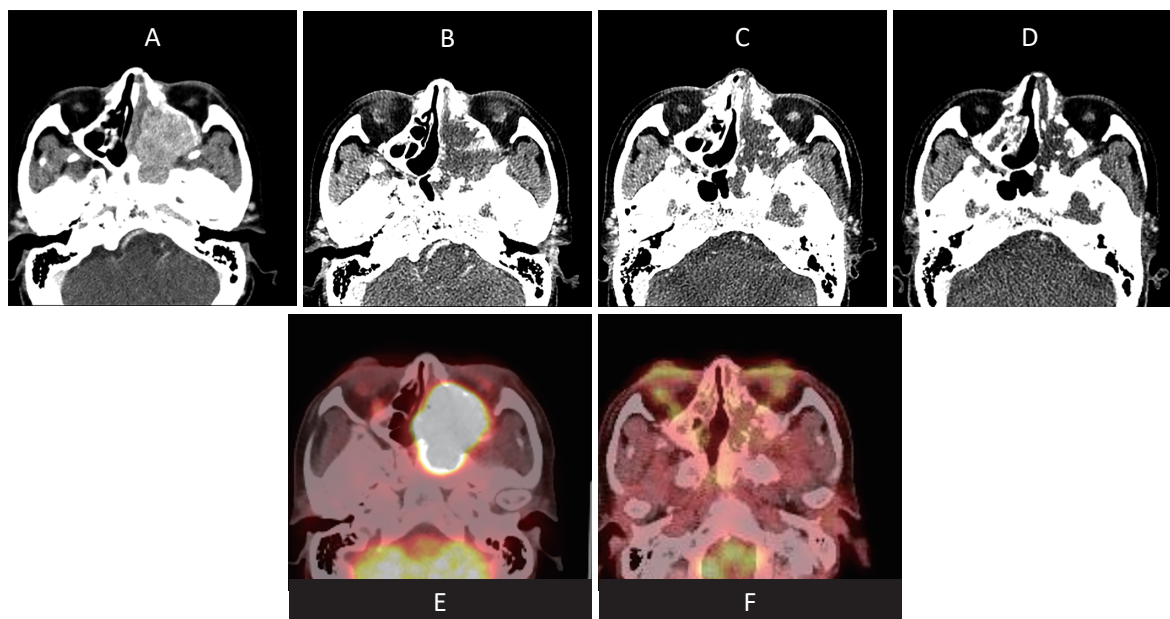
Serial contrast-enhanced computed tomographies are shown, (A) before, (B) after three cycles of cisplatin plus etoposide chemotherapy, (C) after chemoradiotherapy by 4th cycle cisplatin plus etoposide combined with radiotherapy (60Gy) and (D) 4 years after the chemoradiotherapy. Positron emission tomography with fluorodeoxyglucose-computed tomography (FDG-PET/CT) (E) before and (F) after chemoradiotherapy. Positive FDG uptake in the nasal mass was completely diminished after the chemoradiotherapy, suggested complete remission after chemoradiotherapy.
